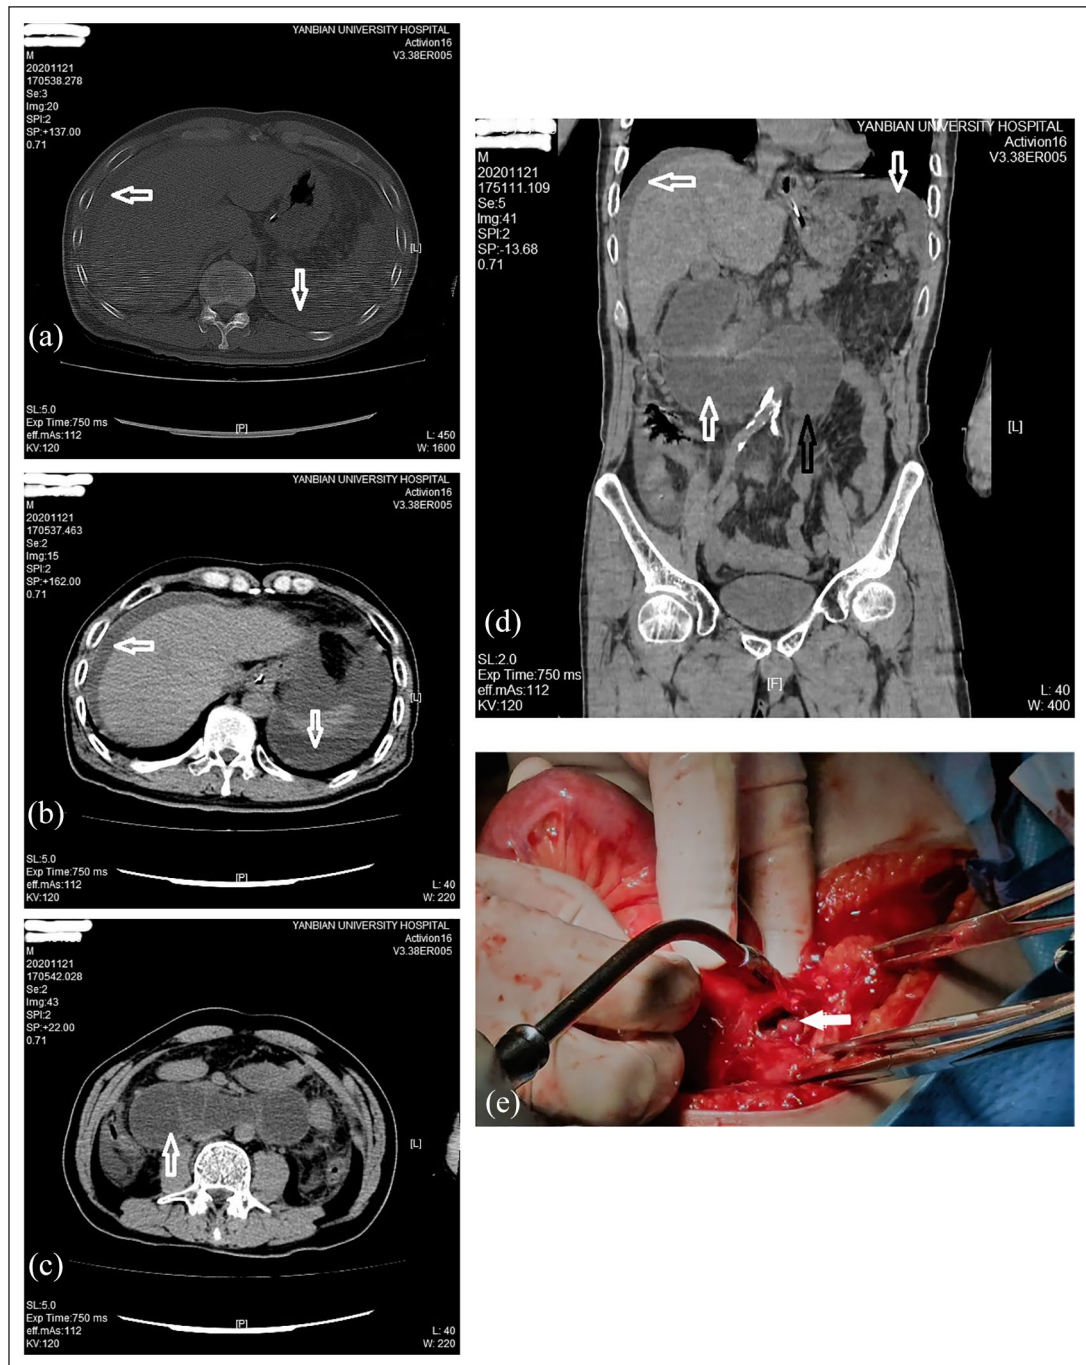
Abdominal CT scans upon admission to our emergency department secured the diagnosis of the A-loop obstruction and further discovered peritoneal effusion. It presented sub-diaphragmatic fluid 5 h after the previous scan (white arrow) (a, b); a dilated and fluid-filled duodenum across the mid-abdomen proximal to the suspected closed-loop obstruction (white arrow) and an obstruction site (black arrow) (c, d); a perforation found on the anterior wall of the horizontal duodenum proximal to the attachment of the Treitz ligament (white arrow) (e).
